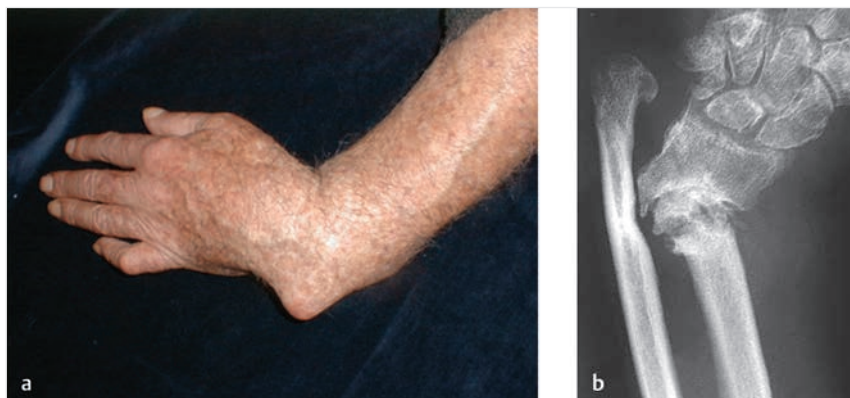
(a) Preoperative photograph showing the “radial club” hand deformity. (b) Anteroposterior and lateral radiographs showing an atrophic nonunion with radial and volar angulation.
